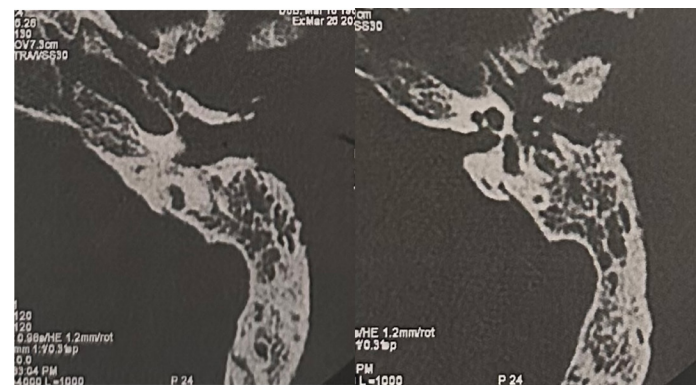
Computed tomography (CT) of the temporal bone (axial view) demonstrating soft tissue opacity within the external auditory canal with extensive bony erosion of the canal walls, extending to the middle ear cavity.
